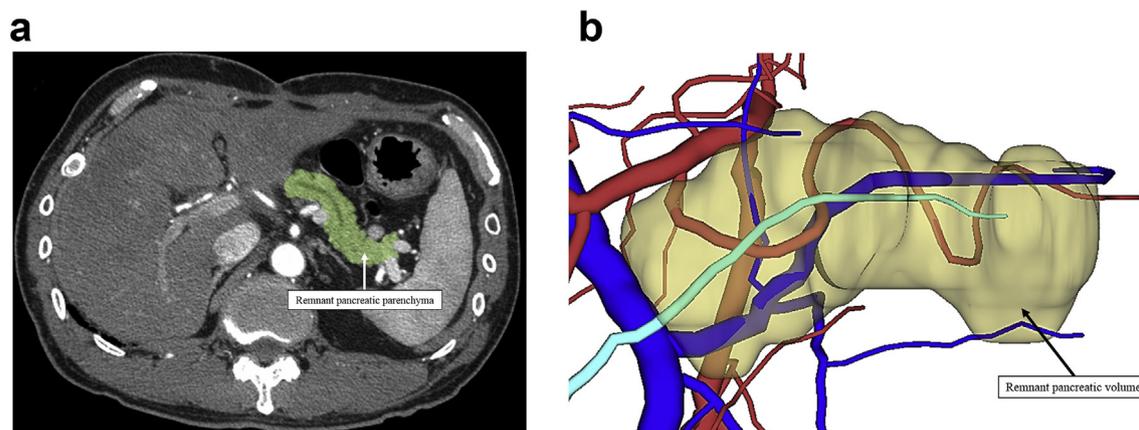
A An integrated multi-detector computed tomography (MDCT) image obtained after the operation is shown. The outlined area indicates the remnant pancreatic parenchyma. Each slice of the remnant pancreatic parenchyma was traced, and the corresponding remnant pancreatic volume was calculated as the sum of the pancreatic tissue areas. B A three-dimensional (3D) image of the remnant pancreatic volume obtained by MDCT images from same patient is shown. This image represents a 3D view from the front of the patient. Ivory represents the remnant pancreatic volume; red represents the arteries; blue represents the veins, including the portal vein; and turquoise represents the main pancreatic duct.
